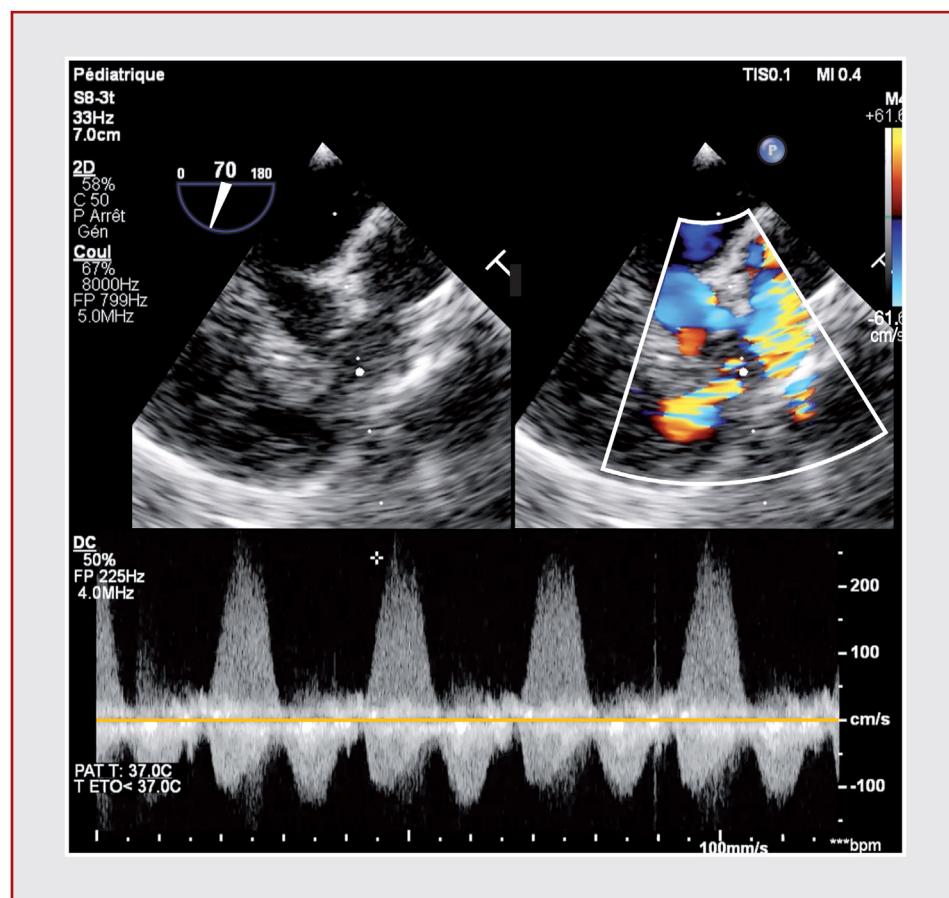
Mild right ventricular outflow tract residual obstruction following tetralogy of Fallot surgery. Upper section: residual infundibular stenosis with colour-flow Doppler; midoesophageal right ventricle in-out view. Lower section: continuous Doppler showing residual acceleration.
